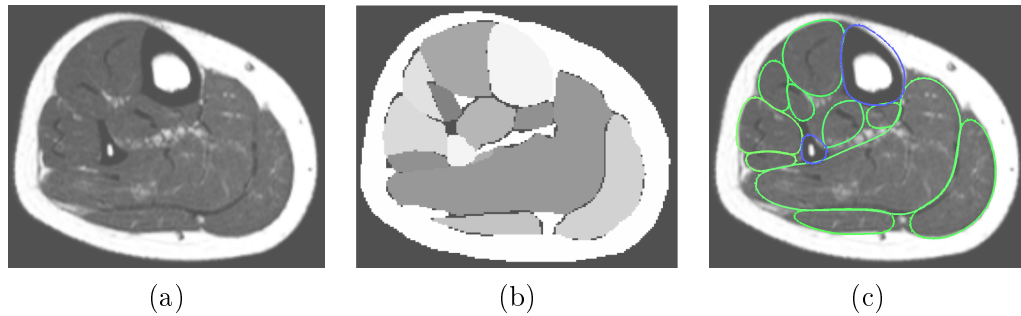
Consecutive steps related to manual delineation. First, (a) an MR image is analyzed by a medical expert (note how difficult it is to see where are muscle boundaries). Then, (b) a manual delineation defines structures of interest by means of labels (a gray value range is used here). Finally, (c) meshes are generated from these labels (contours represent the intersection between MRI slice and generated meshes). Blue contour delineates the tibia bone and green contours delineate the muscles.
